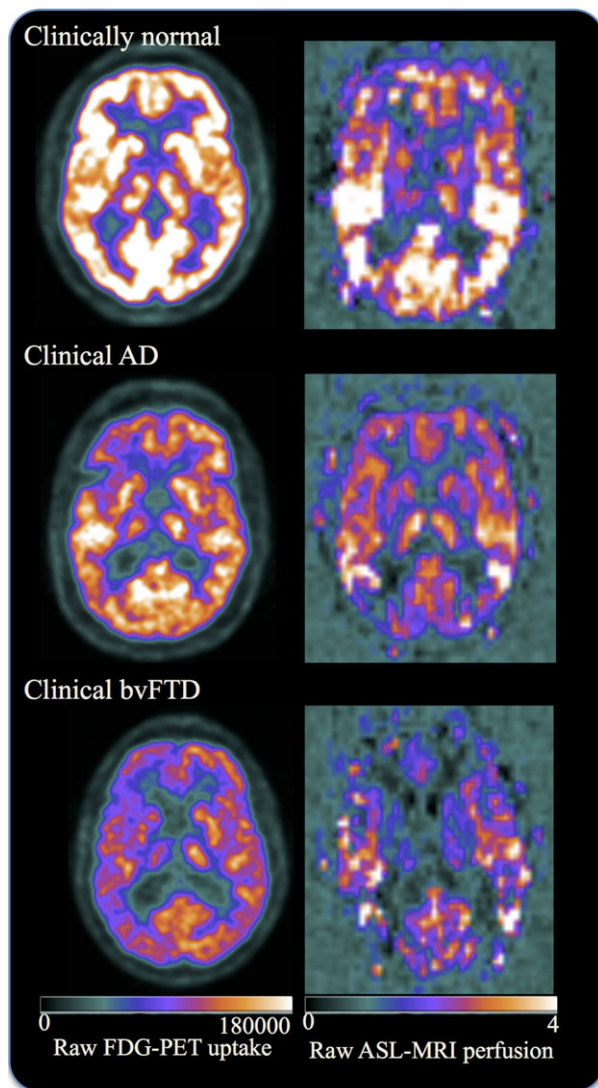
Raw FDG-PET uptake and raw ASL-MRI perfusion maps in selected participants. Images are displayed in neurologic orientation.
